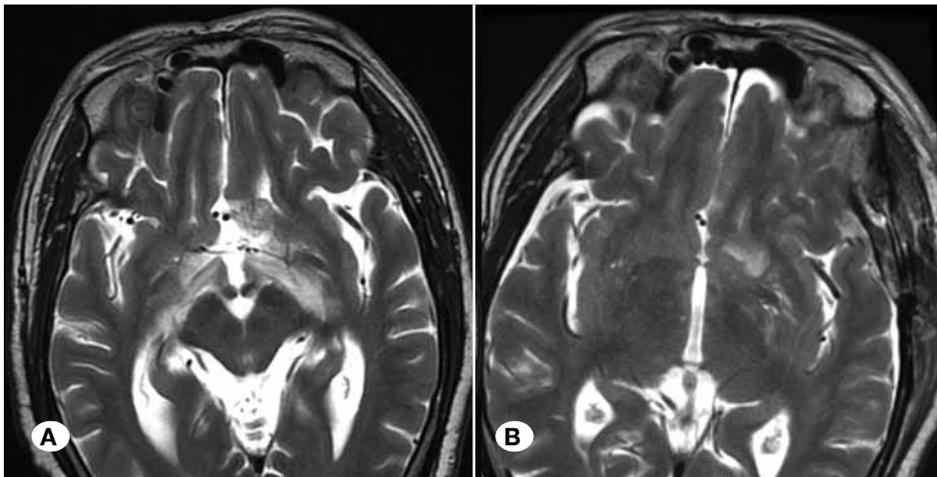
A, B) Pre and postoperative T2-weighted axial images showing bilateral optic tract oedema with complete resolution of the same after surgery.
